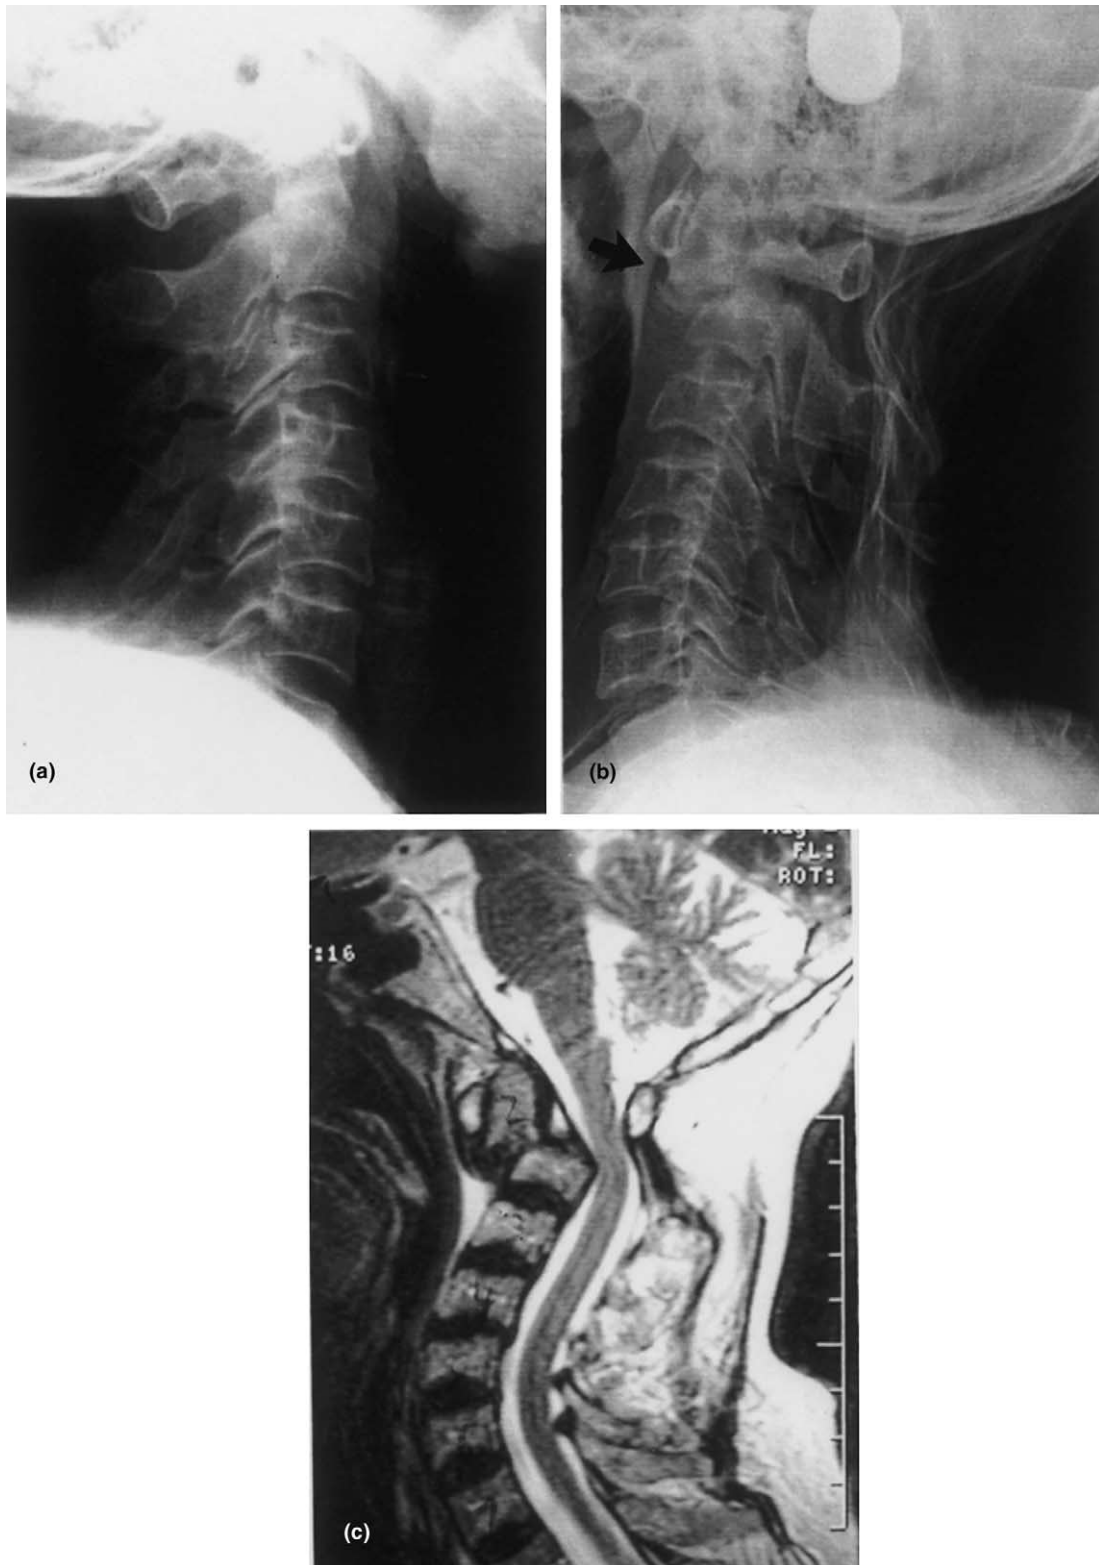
(a) Initial lateral cervical spine showing normal alignment and soft tissue structures; (b) lateral cervical radiographs two months after initial trauma showing marked subluxation of C1 on C2 secondary to odontoid fracture (arrow); and (c) MR image demonstrating the significant canal compromise from the fracture dislocation of C1 on C2.
